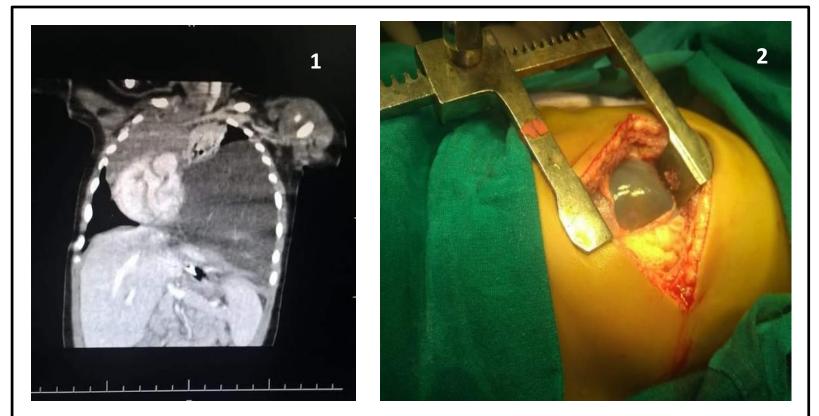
Contrast Enhanced Computed Tomography (Coronal Section) suggestive of Large left sided cystic mass, which mimicked pleural effusion on plain X-Ray; Figure 2 showing visualised cystic mass during Thoracotomy
